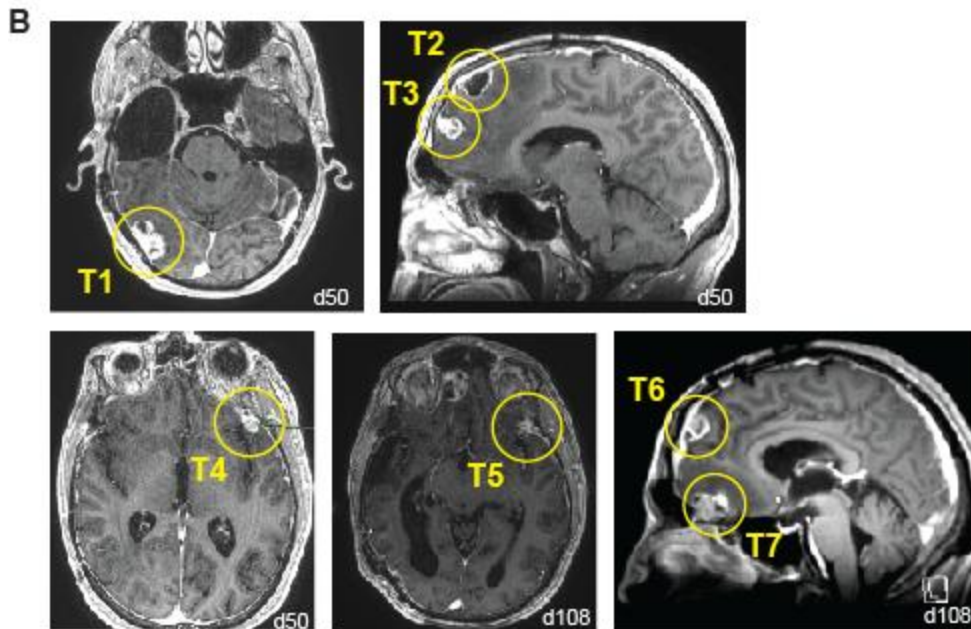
Tumor lesion identification. A, Summary of the patient’s multifocal tumor lesions 1 through 8 (T1-T8), with description of anatomical location, surgical resection and general features. B, Brain MRI scans depicting the sites of tumors 1 through 7 (T1-T7) at the days indicated in the lower right corner of each image.
